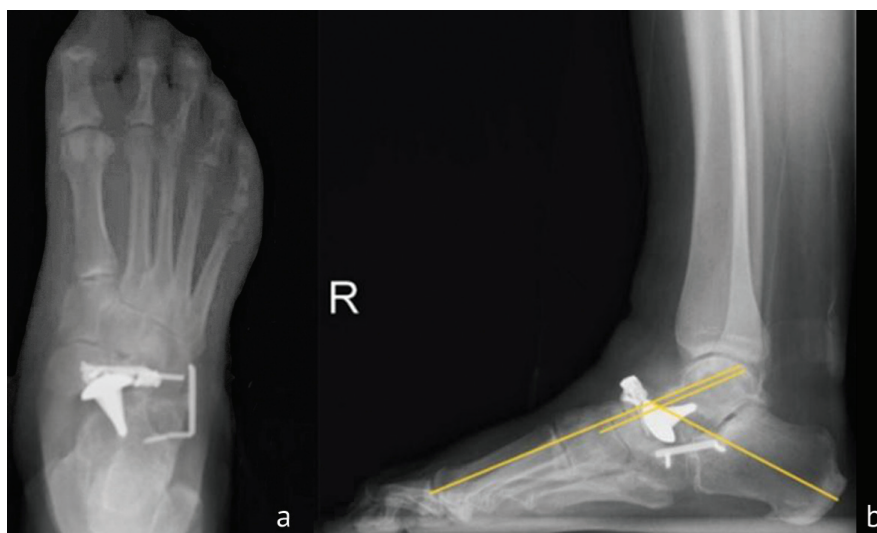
Weight-bearing radiographs of the right foot at 12 months showing (a) AP view; (b) lateral view demonstrating Mary angle of 0°, Kite talocalcaneal angle of 50°. Scaphoid bone healed with MOS, satisfactory calcaneocuboid arthrodesis, broken connector bracket
